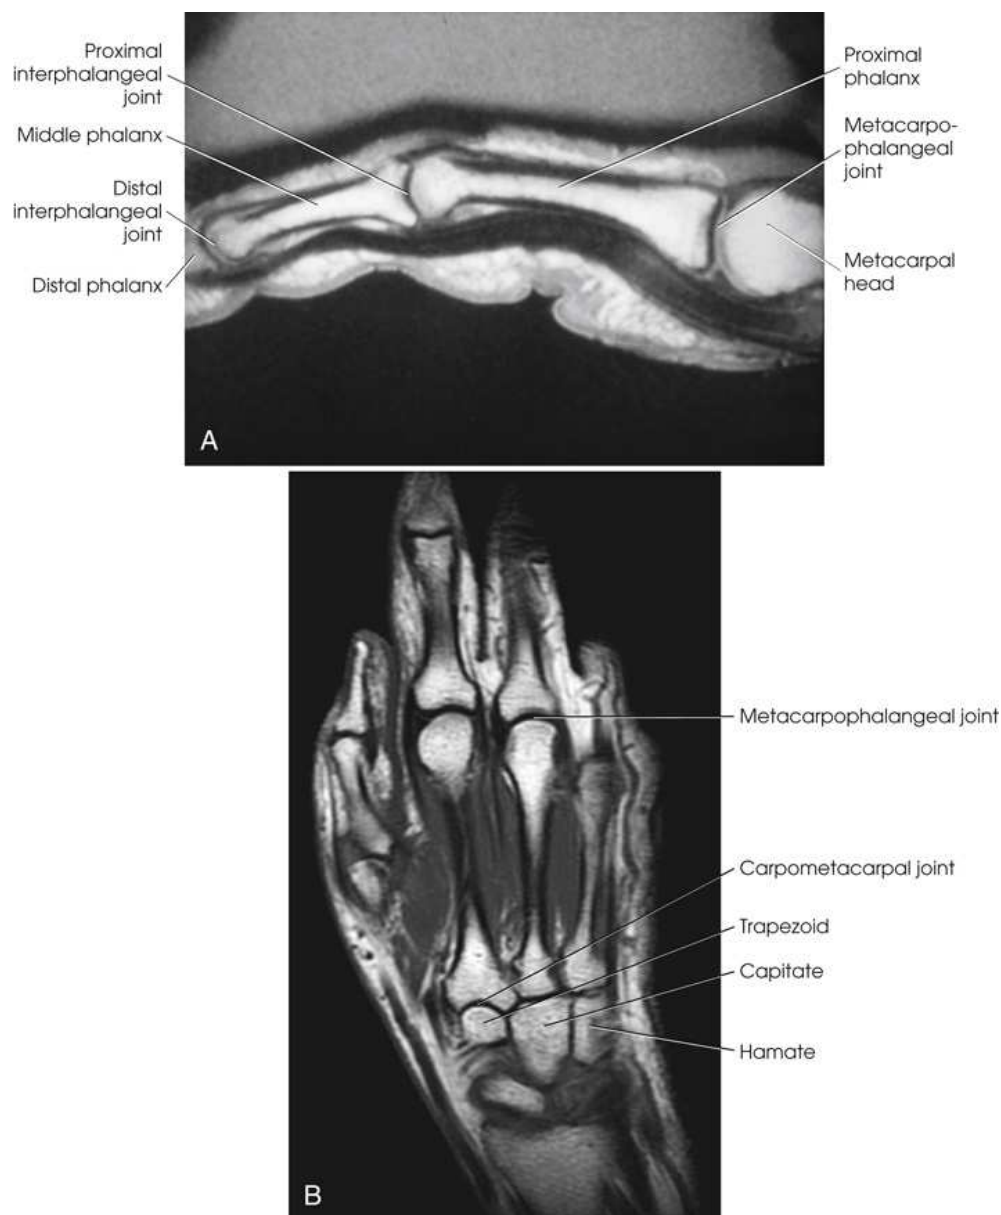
(A) Sagittal MRI of finger showing IP and MCP joints. (B) Coronal MRI of hand and wrist showing same joints.
